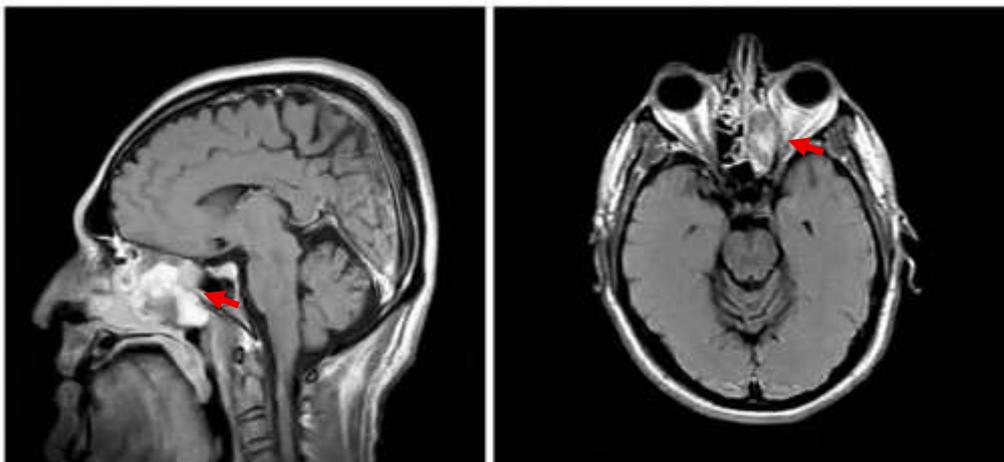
T1-weighted magnetic resonance imaging of the brain reveals a tumor in the left nasal cavity involving regions IV and V.
